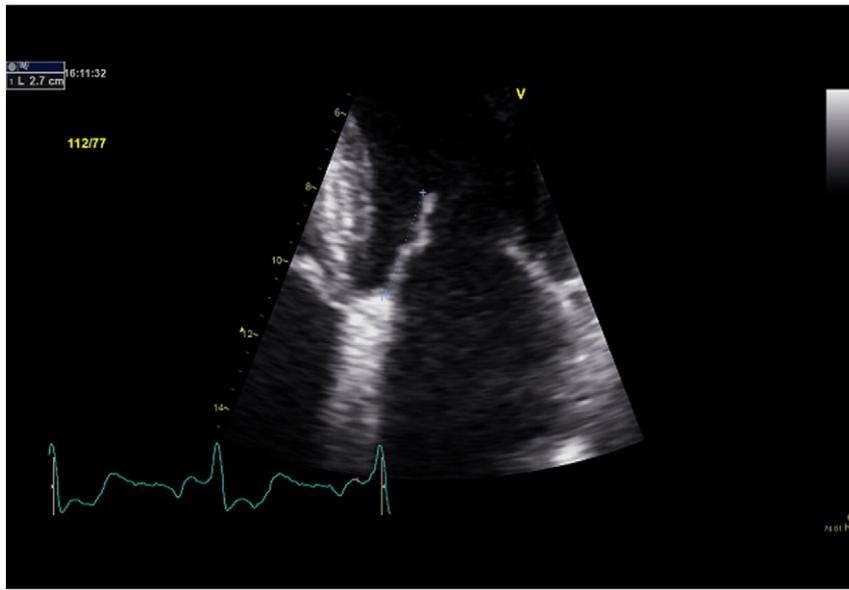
Measurement of anterior mitral leaflet length in apical four-chamber view.
